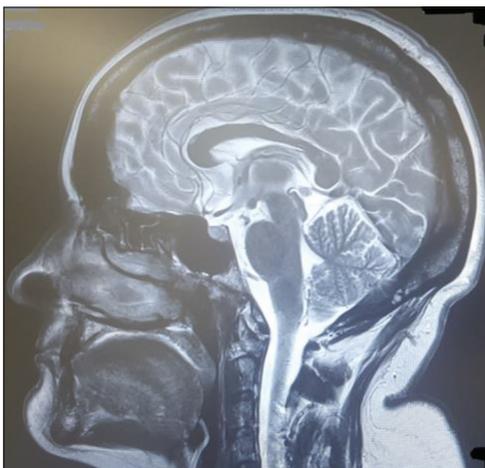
Preshunt adjustment sagittal T2 MRI showing normal 4th ventricle and cistern spaces, no distortion of brainstem or splenium and no tonsillar herniation.
